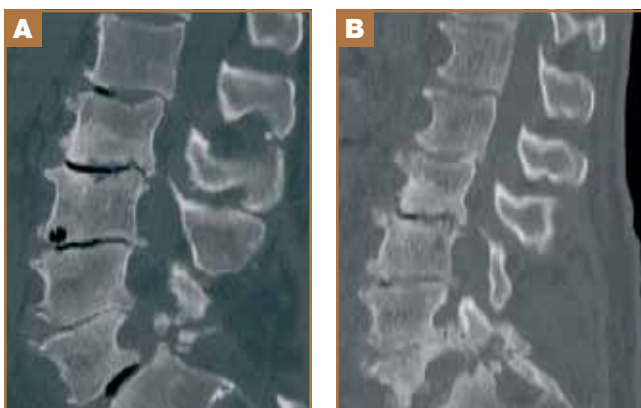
Sagittal computed tomography of lumbar spine at first crisis (A) and second crisis (B) shows progressive erosive changes in L5 vertebral body over 2 months.
